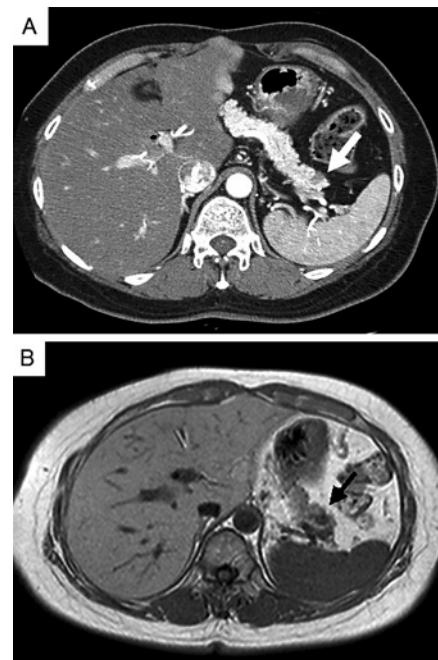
Images of the second operation. A Contrast-enhanced CT showing a small low-density lesion (10 mm in diameter) in the tail of the residual pancreas (arrow). B MRI showing small nodules in the tail of the pancreas (arrow), which had a low intensity on a T1-weighted image and iso-intensity on a T2-weighted image. The nodule was not enhanced by gadolinium EDTA.
